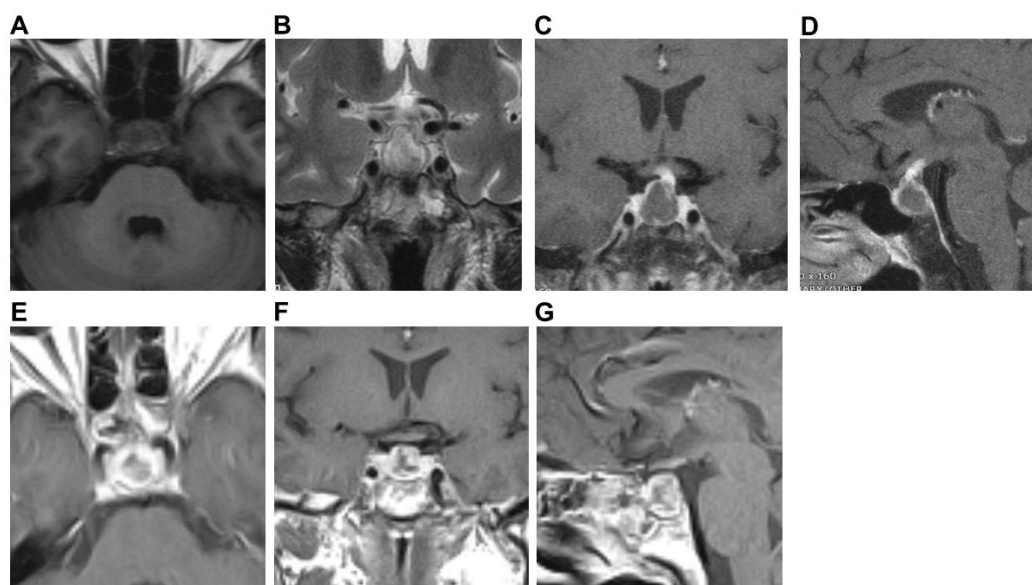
Preoperative pituitary MRI and postoperative MRI of Case 2. Preoperative axial (A) and coronal (B) MRI scans showed cystic lesions in the sellar, T1WI low signal, and T2WI slightly high signal. Preoperative coronal (C) and sagittal (D) MRI enhanced scan showed ring enhancement of the cyst wall, thickening and enhancement of the pituitary stalk, and bilateral cavernous sinus enhancement. Postoperative axial (E), coronal (F), and sagittal (G) MRI showed no recurrence of the pituitary abscess.
